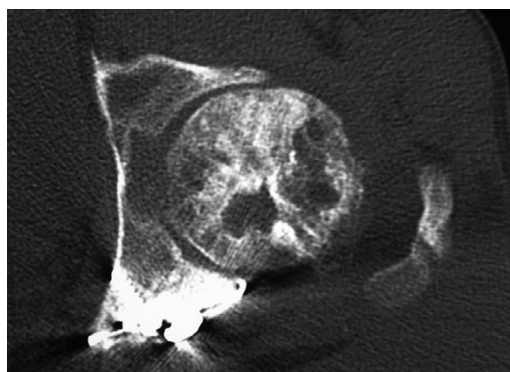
CT scan 18 months post-ACI treatment, showing sclerosis and cysts in the femoral head due to previous osteonecrosis. The joint space is reduced but present, and there is good congruity of the femoral head and acetabulum.
